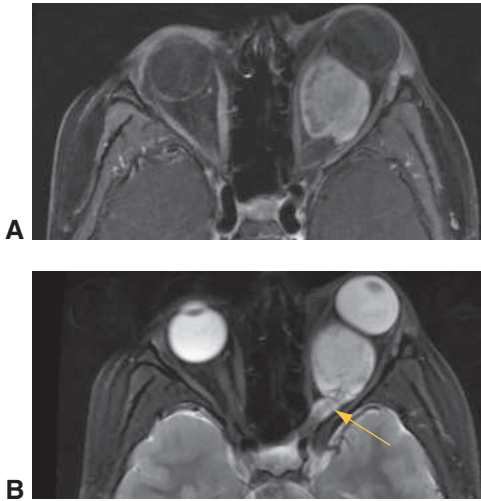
Left optic nerve glioma in a patient with neurofibromatosis type 1 (NF1). T1-weighted axial MRI (A) and T2-weighted axial MRI (B) demonstrate left proptosis from an enhancing retrobulbar mass, with fusiform enlargement of the optic nerve and stereotypical kinking of the nerve (*arrow*). (Courtesy of Gregory D. Avey, MD.)
